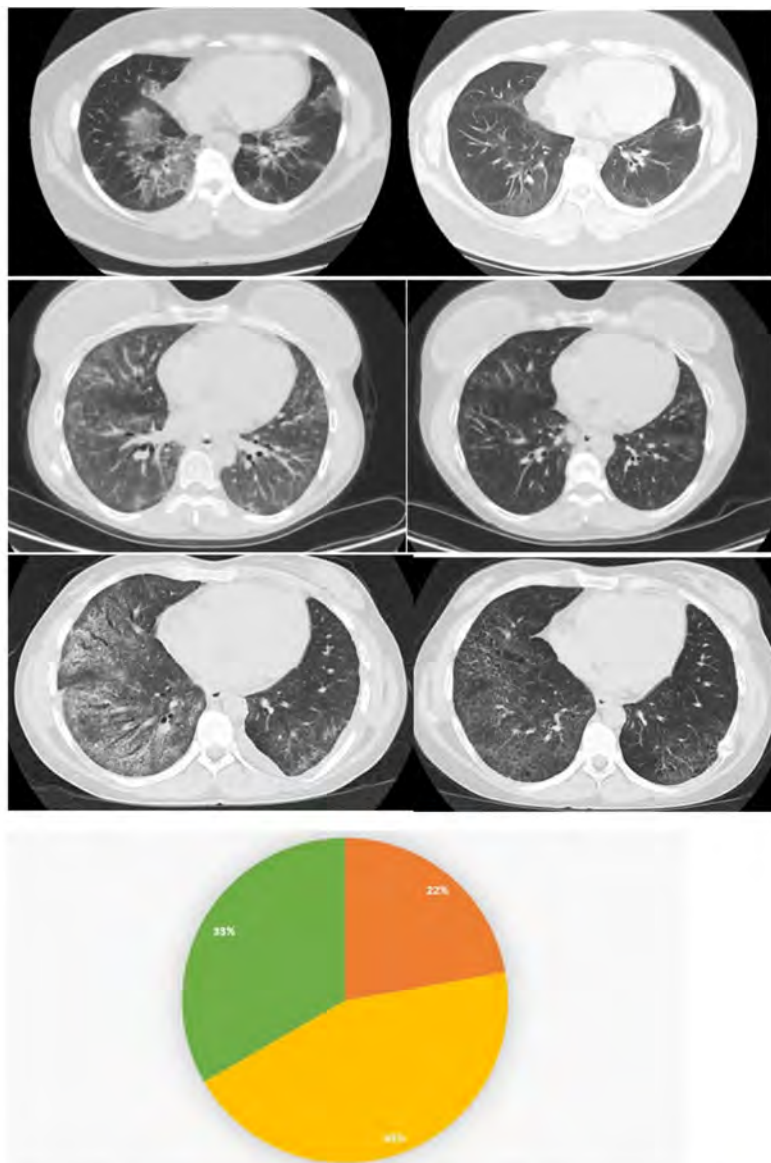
CT scan findings before (left) and after (right) the rituximab therapy showing improvement in three of the 9 patients who had repeat CT chests within two years of the Rituximab therapy. Pie chart (bottom) showing the percentage of patients with stable (yellow), improved (green) and worsened (orange) CT chest findings.
